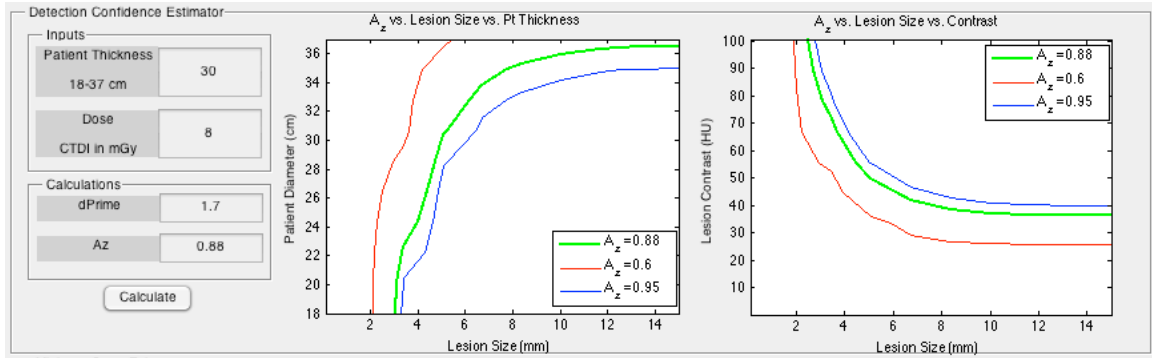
Example of the detection confidence section of the CT protocol evaluator platform.
